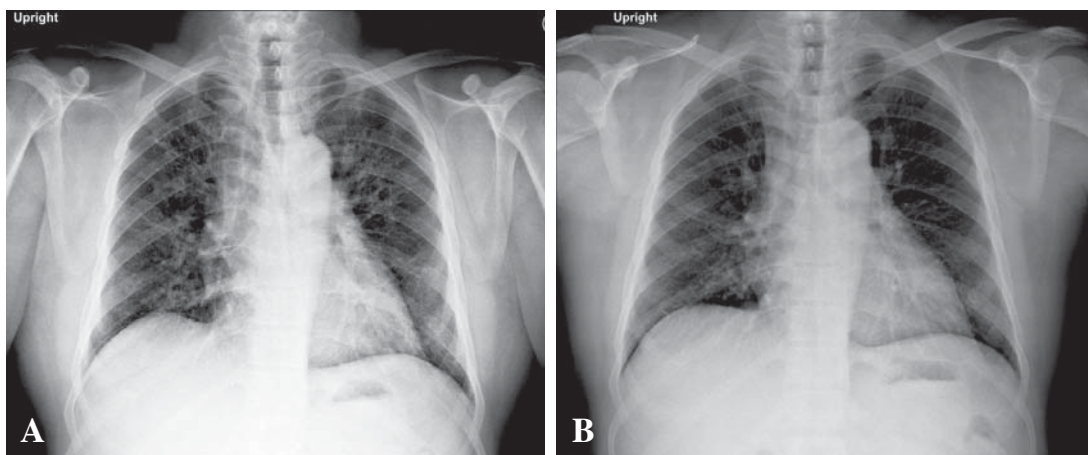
A. Day 21, Further reduction in bilateral infiltration in comparison to the third chest x-ray.
